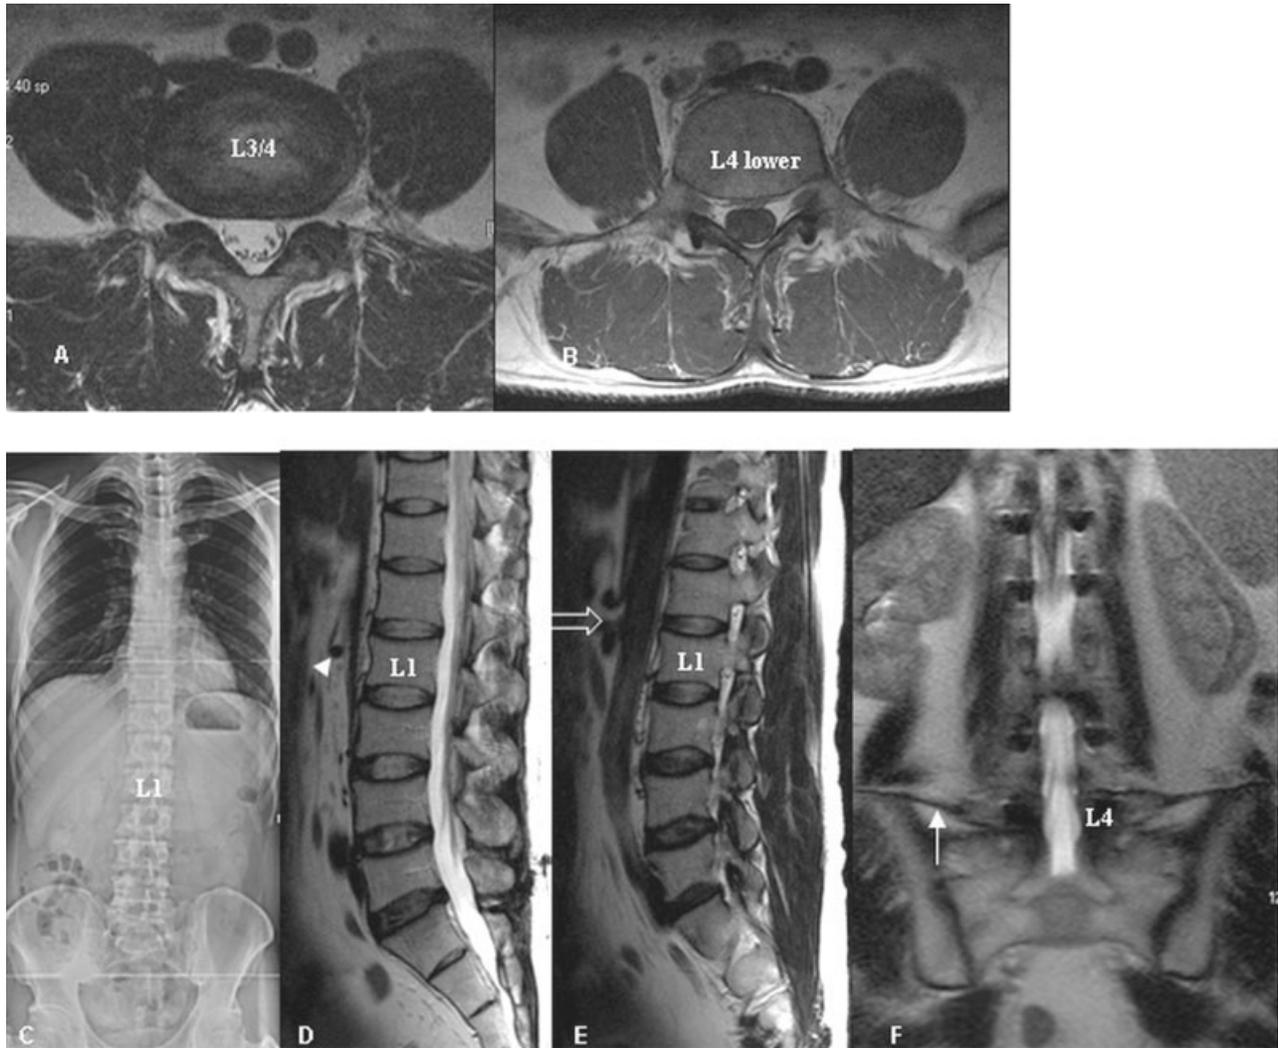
Thirty-nine-year-old man with L5 sacralization. Note that the paraspinal structures are positioned more cephalad than normal. A: Axial T2 WI shows the aortic bifurcation at the level of the L3-4 disc space. B: Axial T1 WI reveals IVC confluence at the lower half of L4. C: In the lumbar AP radiograph, the L5 vertebra shows the complete type of sacralization. The 12th rib is also absent. D: Sagittal T2 WI shows the proximal right renal artery (arrow head)
